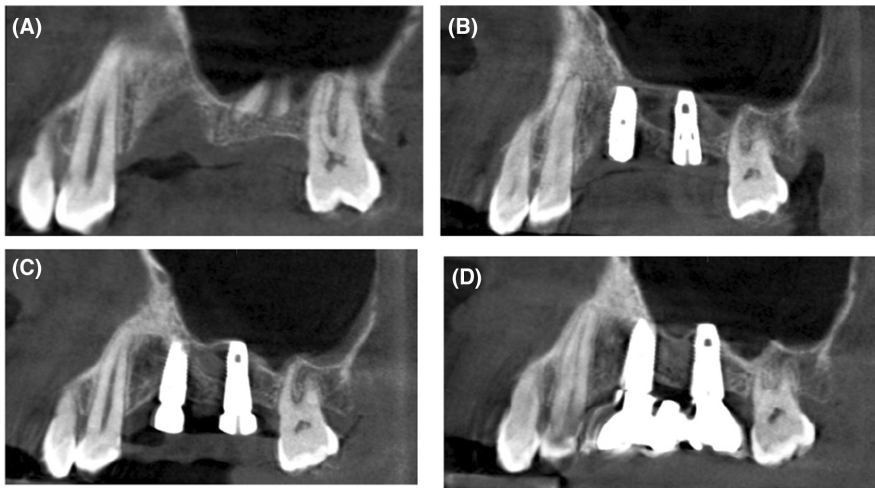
CBCT images of a 1-stage lateral window approach using L-PRF as sole substitute (A); pre-op situation, (B); immediate post-op, (C); 4 months' implant uncovering before loading, and (D); 2 years post loading; notice the increase in bone density over time.
